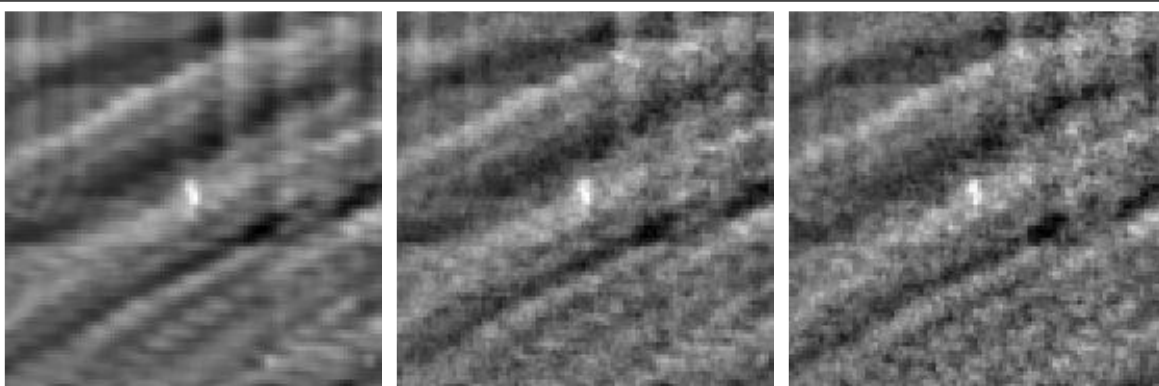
Effect of quantum noise on detectability. (Left) Noiseless case. (Middle) Noise assuming 60 kVp @ 6 mAs, and 140 kVp + Sn @ 1 mAs. This dose is roughly equivalent to a standard chest x-ray. (Right) Noise assuming 60 kVp @ 3 mAs, 140 kVp + Sn @ 0.5 mAs, or half dose.
